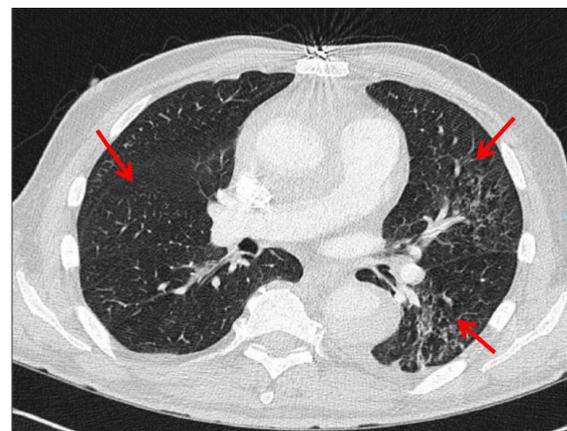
CT Thorax 25.07.15: Bilateral atypical pulmonary Infiltrates (arrows).
